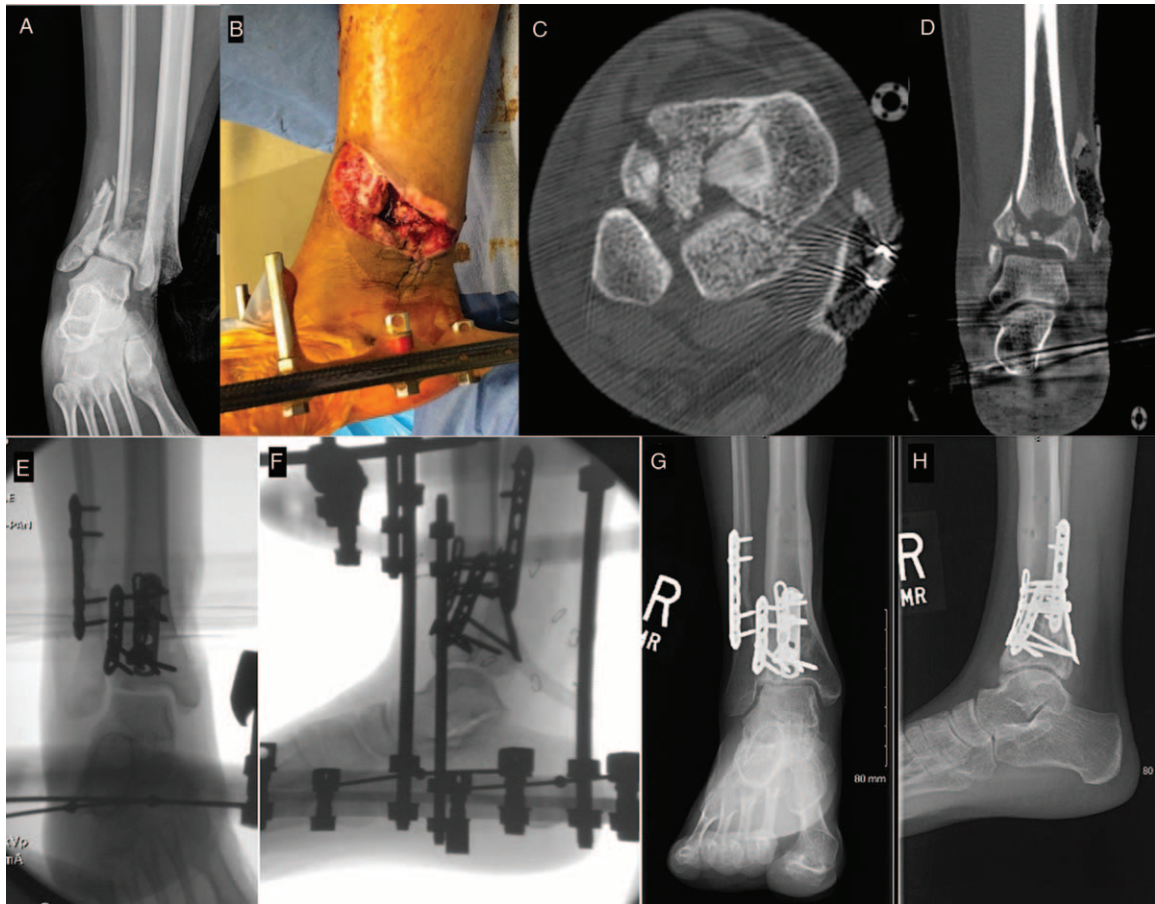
Case 1, pilon fracture. (A) AP x-ray of injury. (B) Clinical photo of soft tissue injury. (C) Axial CT image. (D) Coronal CT image. (E) AP fluoroscopic image of final fixation construct. (F) Lateral fluoroscopic image of final fixation construct. (G) AP x-ray at 26 months postoperatively. (H) Lateral x-ray at 26 months postoperatively.
